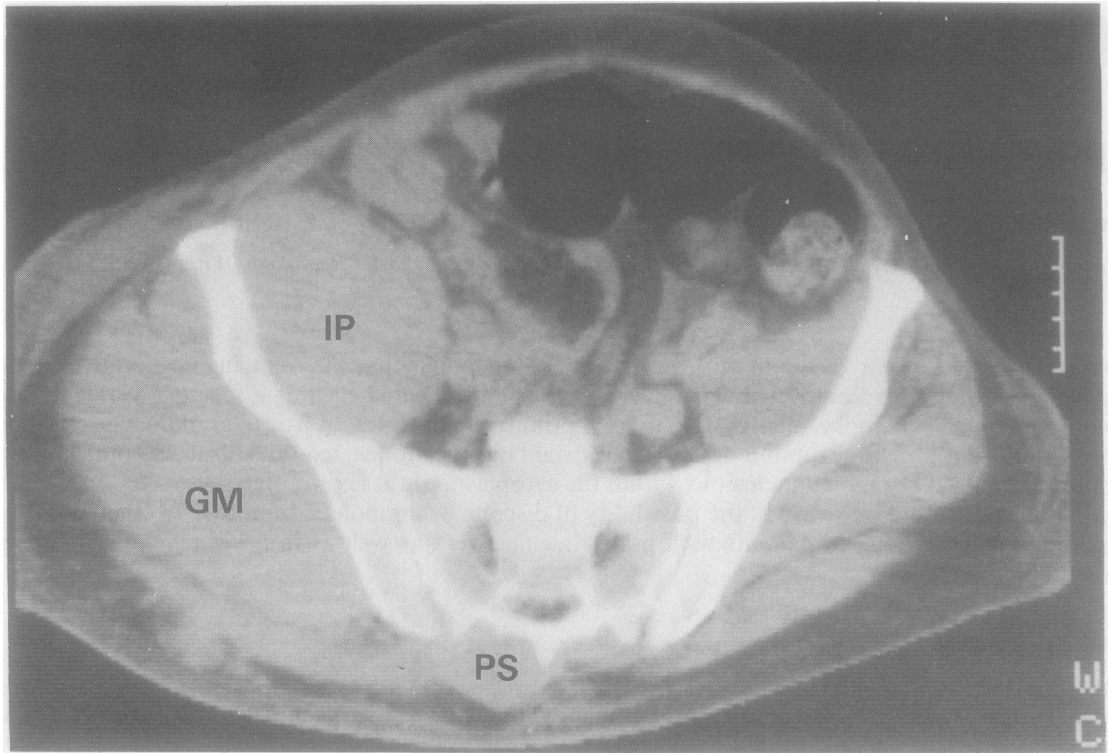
Computed tomography scan of abdomen showing swelling of right iliopsoas (IP), posterior spinal (PS), and gluteus medius (GM) muscles.
